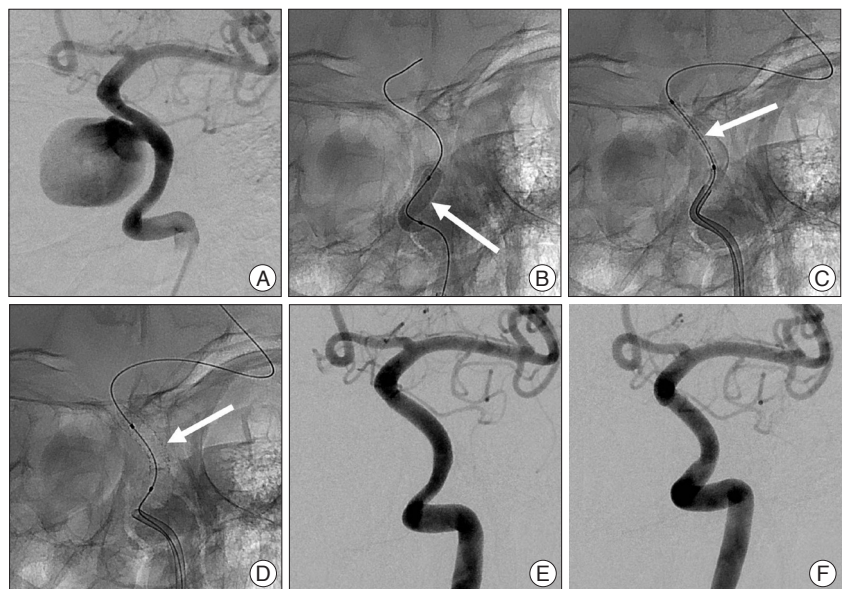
A left internal carotid artery (ICA) angiogram (A) revealing the pseudoaneurysm in the cavernous portion, measuring 37×32 mm. Radiography (B) showing the balloon test occlusion (arrow) using a 4×20 mm balloon. Radiography (C) demonstrating a 4/26 mm-sized graft-stent (arrow) which was advanced over the microwire and positioned across the neck of the pseudoaneurysm just before stent deployment. After successful deployment of the graft-stent (arrow) across the aneurysmal neck (D), left ICA angiogram (E) revealing normal patency of the ICA and perfect sealing of the aneurysm neck with no opacification of the sac. A left ICA angiogram (F) obtained 10 months after the intervention showing the stable occlusion of the pseudoaneurysm and no alteration of the patency of the ICA.
